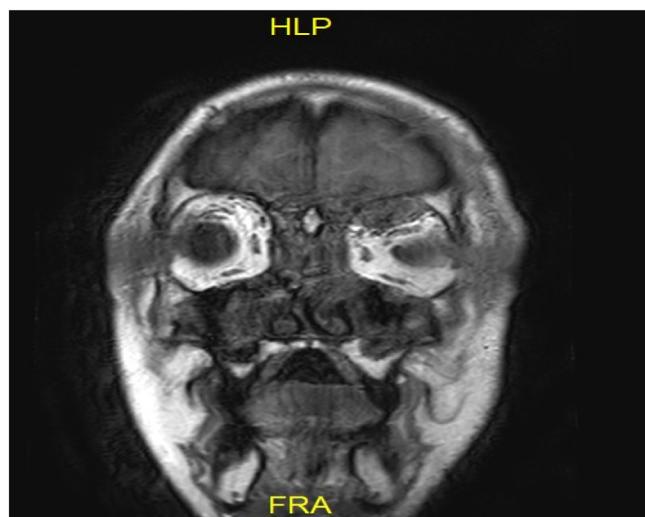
MRI showing traumatic left orbital encephalocele appears to be contiguous with a left frontal hemorrhagic contusion.
